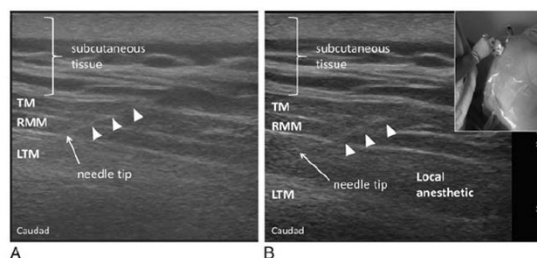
The ultrasound-guided ESP block performed superficial to erector spinae muscle (ESM) in the first patient of the case series. Inset picture shows patient in seated position with probe placed in a parasagittal plane 3 cm lateral to the midline at the level of the fifth thoracic vertebra. A, The needle (arrowheads) is inserted in a cephalad-to-caudal direction to place the tip between the rhomboid major muscle (RMM) and ESM. B, Injection here creates a linear pattern of local anesthetic spread that displaces the ESM downward.
